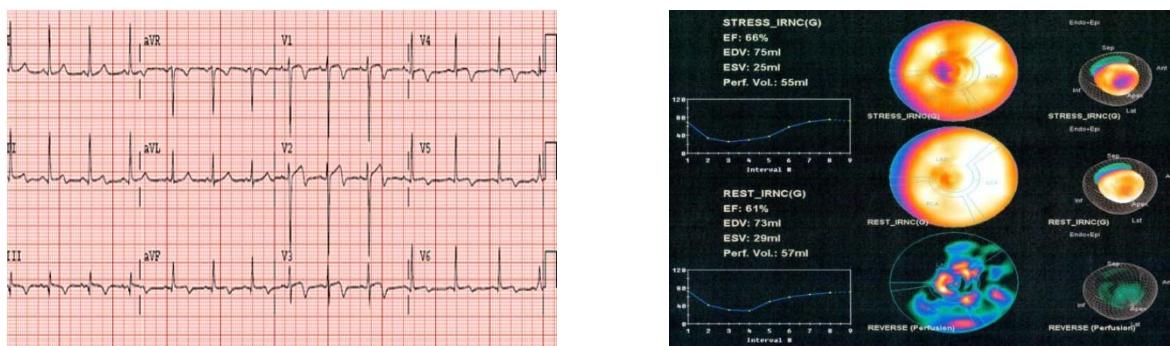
Clinical case 1: 58 y.o. male, NSCL of LAD, FFR-0.82 and apical perfusion defect on stress-rest SPECT, NSTEMI after 6 months from MPI.
